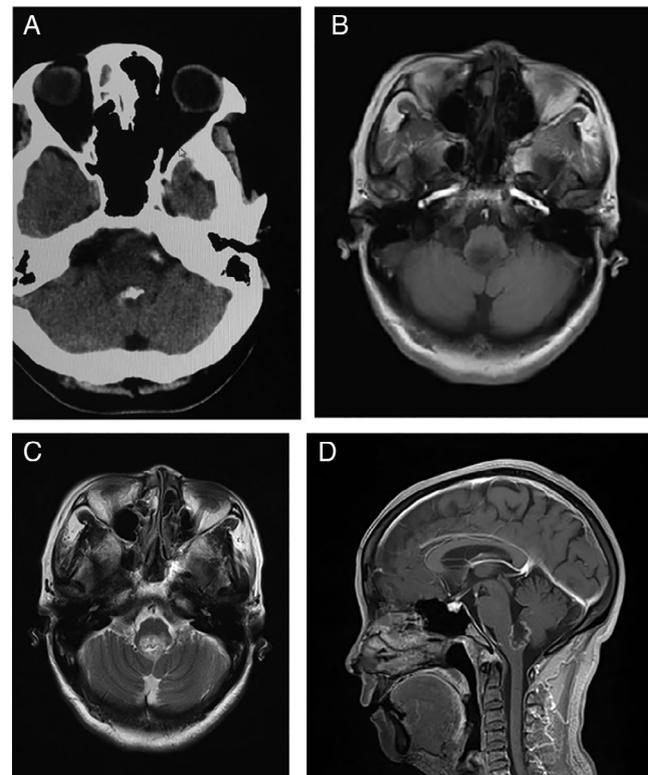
CT (A) and MRI (B-D) findings of the brain. CT reveals irregular calcification in the fourth ventricle (A). Axial T1-weighted (B) and T2-weighted (C) images show a round lesion with long T1 and heterogeneous T2 signals. A sagittal T1-weighted image with gadolinium contrast shows a heterogeneously enhanced ring-like lesion involving the medulla oblongata and extending into the fourth ventricle (D).
